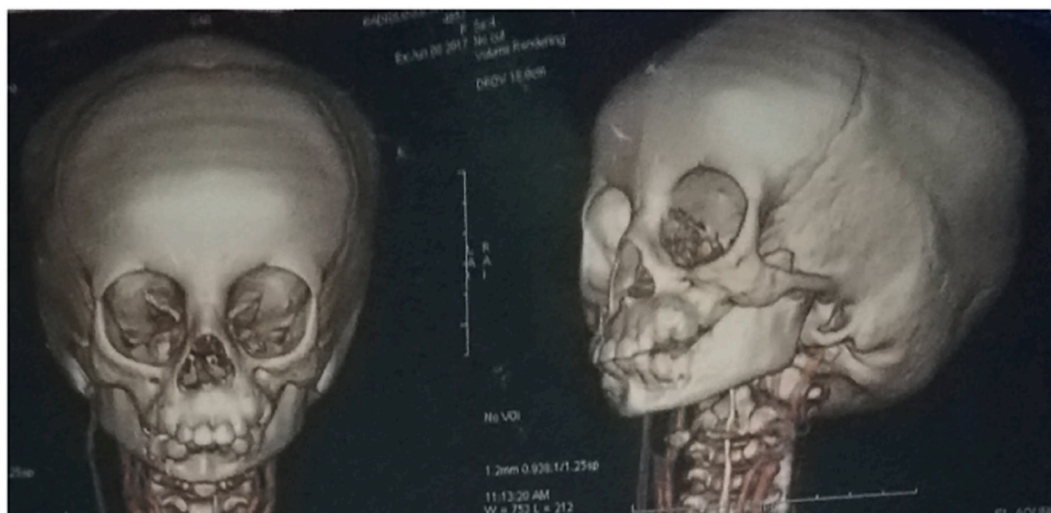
Three-dimensional CT scan showing bilateral fusion of the maxillary and mandibular ridges.
